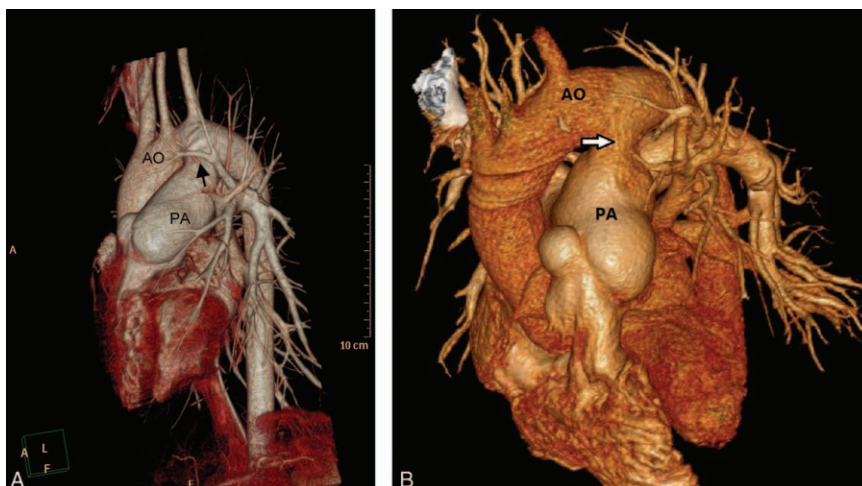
(A) MDCT of the younger brother revealed a large, nonrestrictive type PDA, 2.1 cm in diameter (arrow). (B) MDCT of the elder brother also showed a large (2.4 cm) PDA (arrow). AO=aorta, MDCT = multidetector computed tomography, PA=pulmonary artery, PDA = patent ductus arteriosus.
